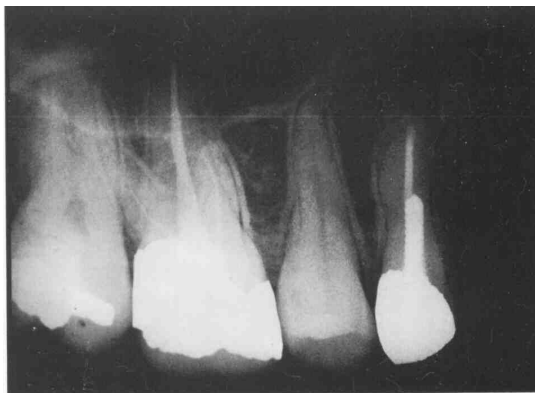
Pre-operative radiograph of a maxillary first premolar tooth restored with a prefabricated post and an amalgam restorative material. Note the thin dentine on the mesial side of the post near its apical area.
